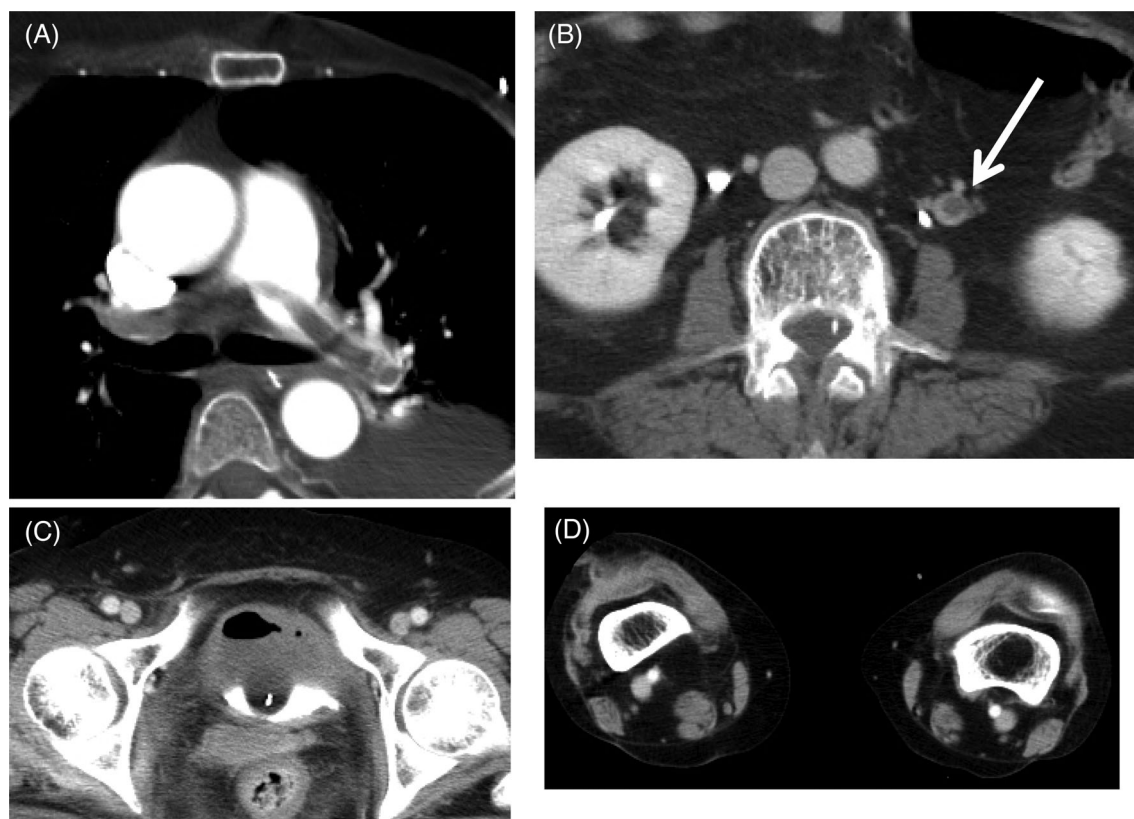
Computed tomography image showing deep vein thrombosis–pulmonary thromboembolism (PTE) protocol findings. (A) massive bilateral PTE. (B, arrow) Dilated and thrombosed left ovarian vein. No thrombus can be found in the proximal sites of the femoral veins (C) and popliteal vein (D).
